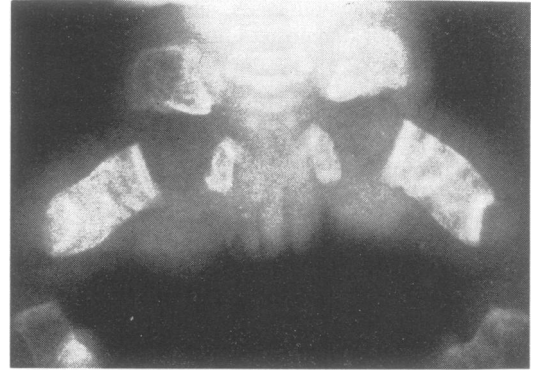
Lethal perinatal OI. X-ray of lower limbs showing a crumpled accordion-like appearance of the femora.
